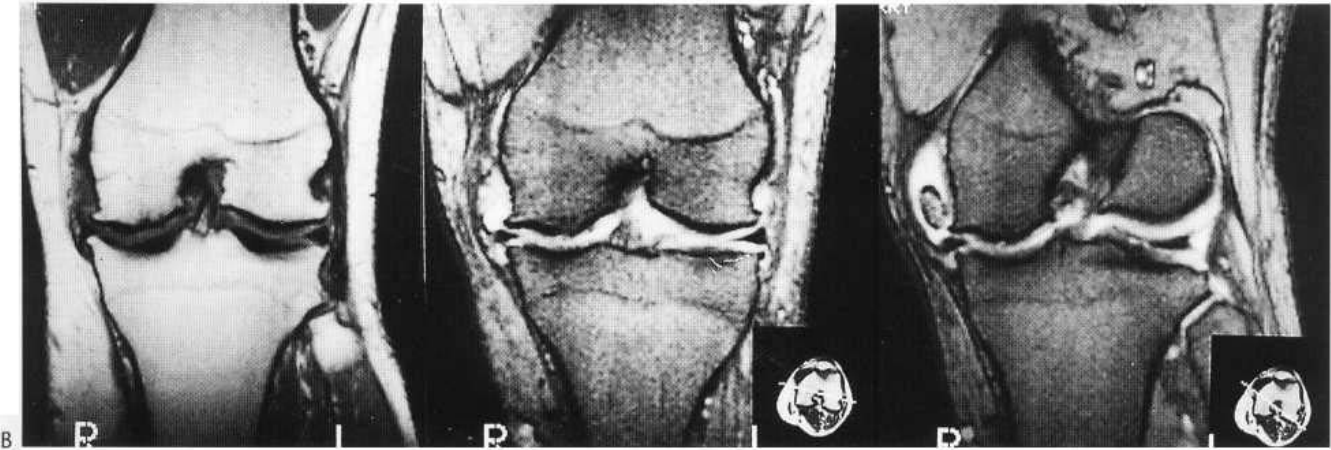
Osteoarthritis. (A) Right shoulder arthrogram. There is irregularity of the synovium and numerous loose bodies are demonstrated within the joint space. There is also a small rotator cuff tear. (B) MRI demonstrates degenerative changes of the knee with an effusion, loss of the medial meniscus, marginal osteophytosis and a large loose body lying medially within the joint.
